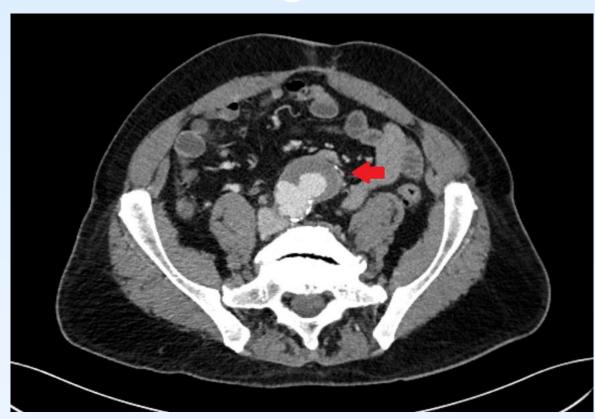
CT abdomen/pelvis with contrast showing saccular aneurysm of abdominal aorta
